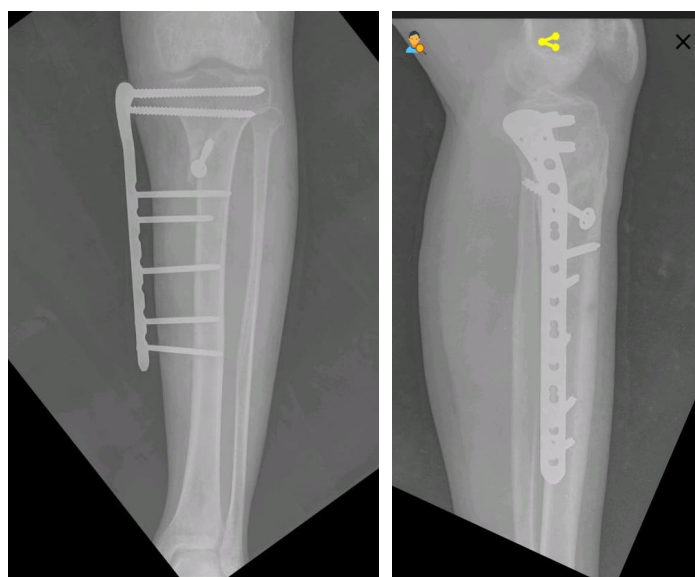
Postop X-ray AP and Lat. viewat3rdmonth
